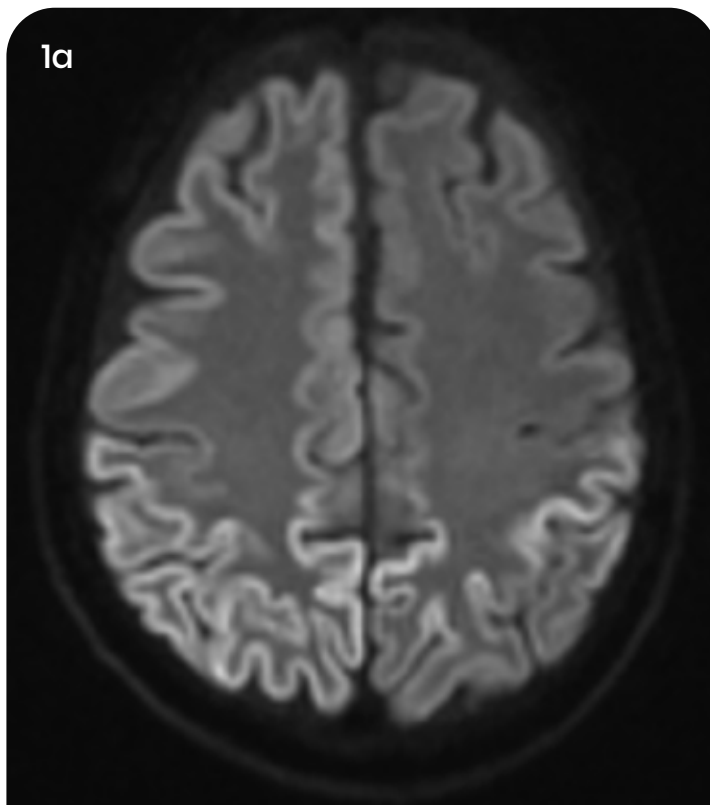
Gyriform hyperintense signal (cortical ribbon sign) along cerebral cortex on DWI in high parietal region involving bilateral post central sulcus.
